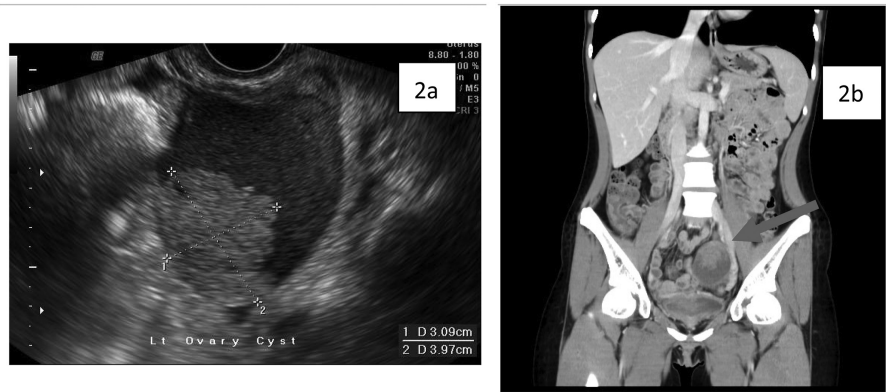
Image studies before first fertility sparing debulking operation. (a)transvaginal ultrasonography: a papillary projection inside the left adnexal cyst; (b) coronal view of computed tomography of pelvis and abdomen (arrow) revealed the origin tumor location.
